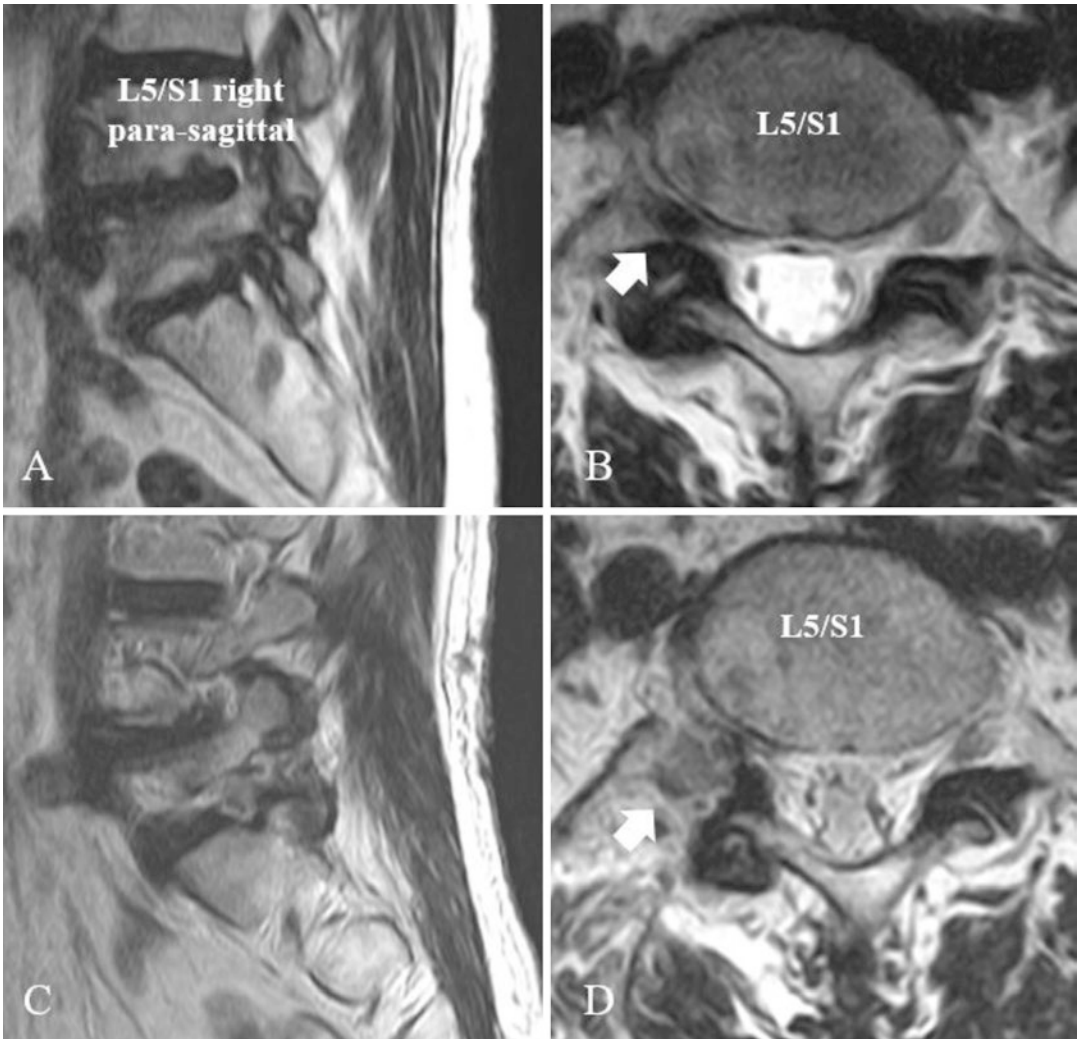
Preoperative MRI images show foraminal HLD L5/S1 right side (a and b). Postoperative MRI images show complete removal of HLD at right foramen (c and d)
